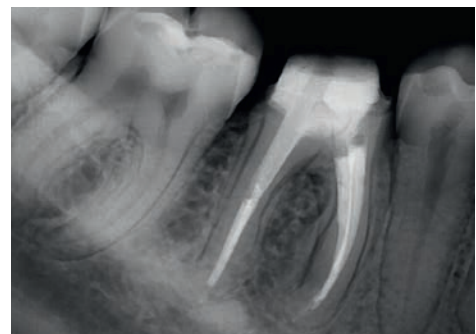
CBCT sagittal image (5-month follow-up).
